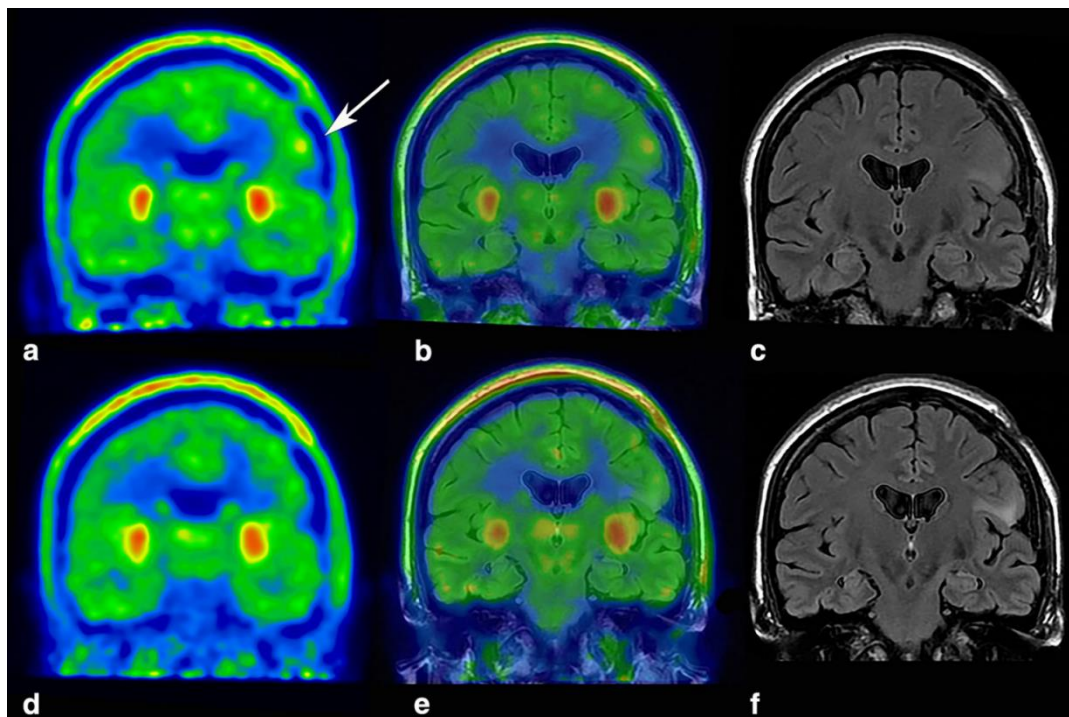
a Coronal view of the [^{18}F] FDOPA scan in a person with primary brain tumor grade II. It shows the focal area (arrow) with increased uptake of radiolabeled compounds in the left frontal lobe of the surgical margin. The SUVr was equal to 1.17. In b, we report on PET / MRI fusion imaging, and in c, we
